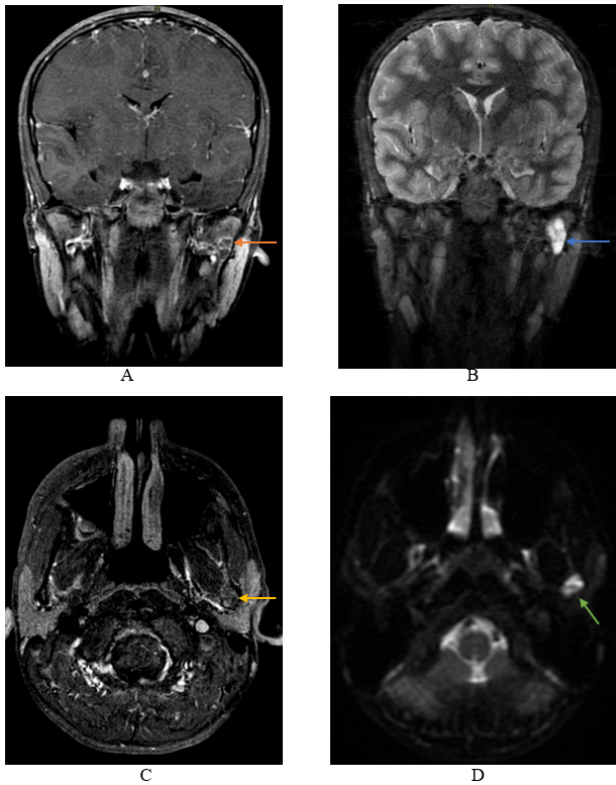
Multisequence enhanced MRI of the head. A and C): Coronal and axial T1-weighted fat-saturated (FS) post gadolinium sequences demonstrate a heterogeneously enhancing mass in the left mandibular ramus (orange arrows). B and D): Coronal and axial T2-weighted FS sequences demonstrate fluid signal within this mass (blue arrow) as well as the presence of a fluid-fluid level (green arrow)
